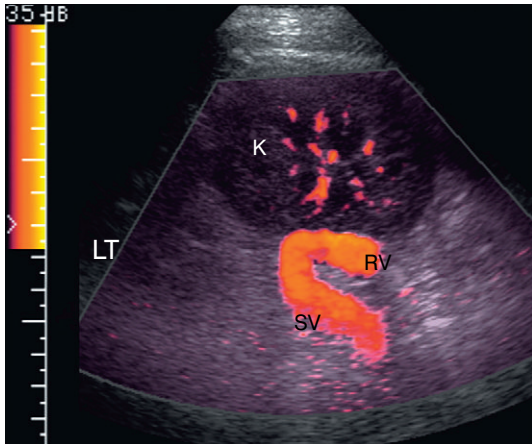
Oblique longitudinal view of the left flank focused at the upper pole of the left kidney. The candy cane shaped large vessel is identified. The upper portion represents the splenic vein with flow coursing towards the transducer. It has been hooked in surgically to the renal vein. The patient is status postsplenectomy anastomosis of the distal splenic vein to the renal vein. The anastomosis is widely patent with flow confirmed by Doppler.
